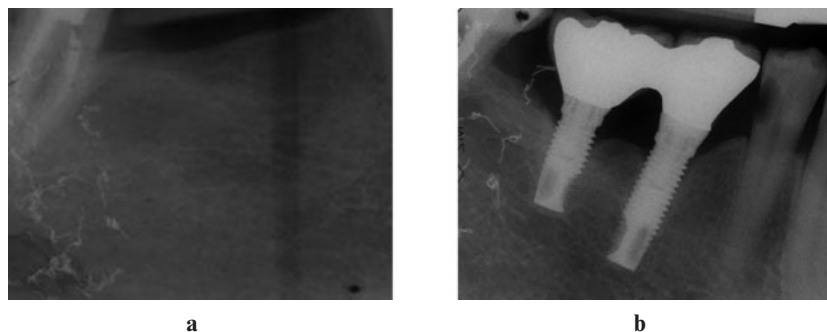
Intraoral radiographs of the mandibular right molar area (a) before and (b) after implant insertion
